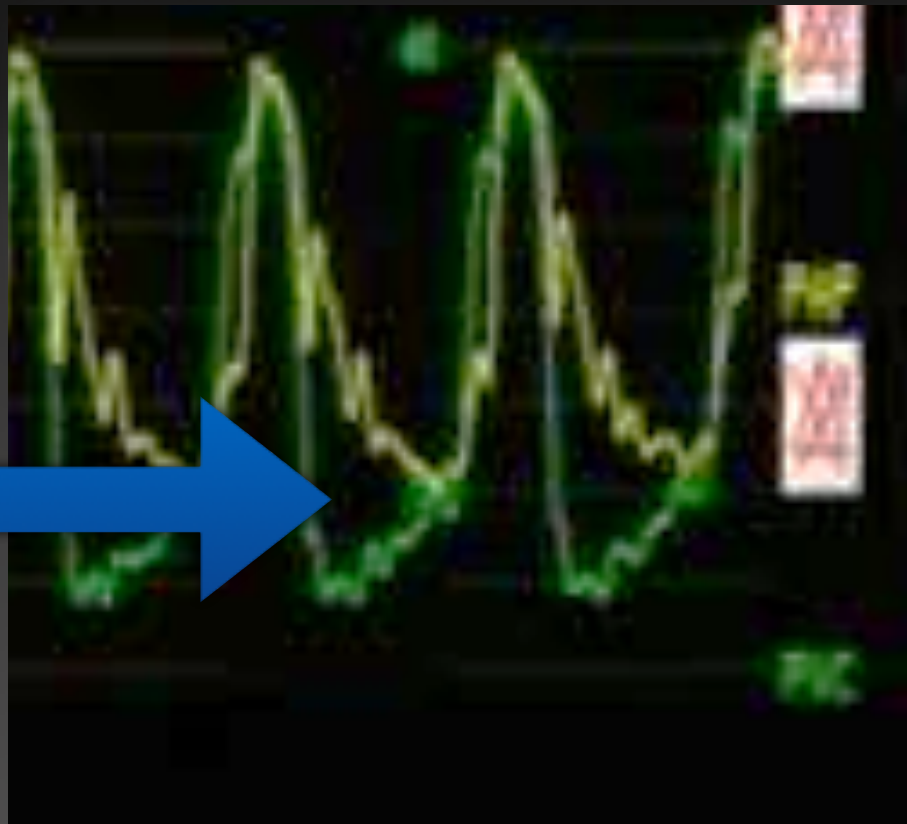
(A,B) Echocardiographic and hemodynamic definition for normal and abnormal (C-F) right ventricular function using hepatic venous flow (HVF) variables, right ventricular pressure (Prv), and pulmonary artery pressure (Ppa) (dotted line) waveforms. Note that as right ventricular function deteriorates, the Prv waveform changes from a (A) normal horizontal to an (C) oblique and then a (D) square root waveform. The latter is associated with Ppa diastolic equalization. Note also that as right ventricular function deteriorates, the S/D ratio > 1 (B) becomes < 1 (E) and the S wave flattens or can even become inverted (F) (AR, HVF atrial reversal; D, diastolic component of the HVF; S, systolic component of the HVF). (Adapted from Denault 2013²⁰).
